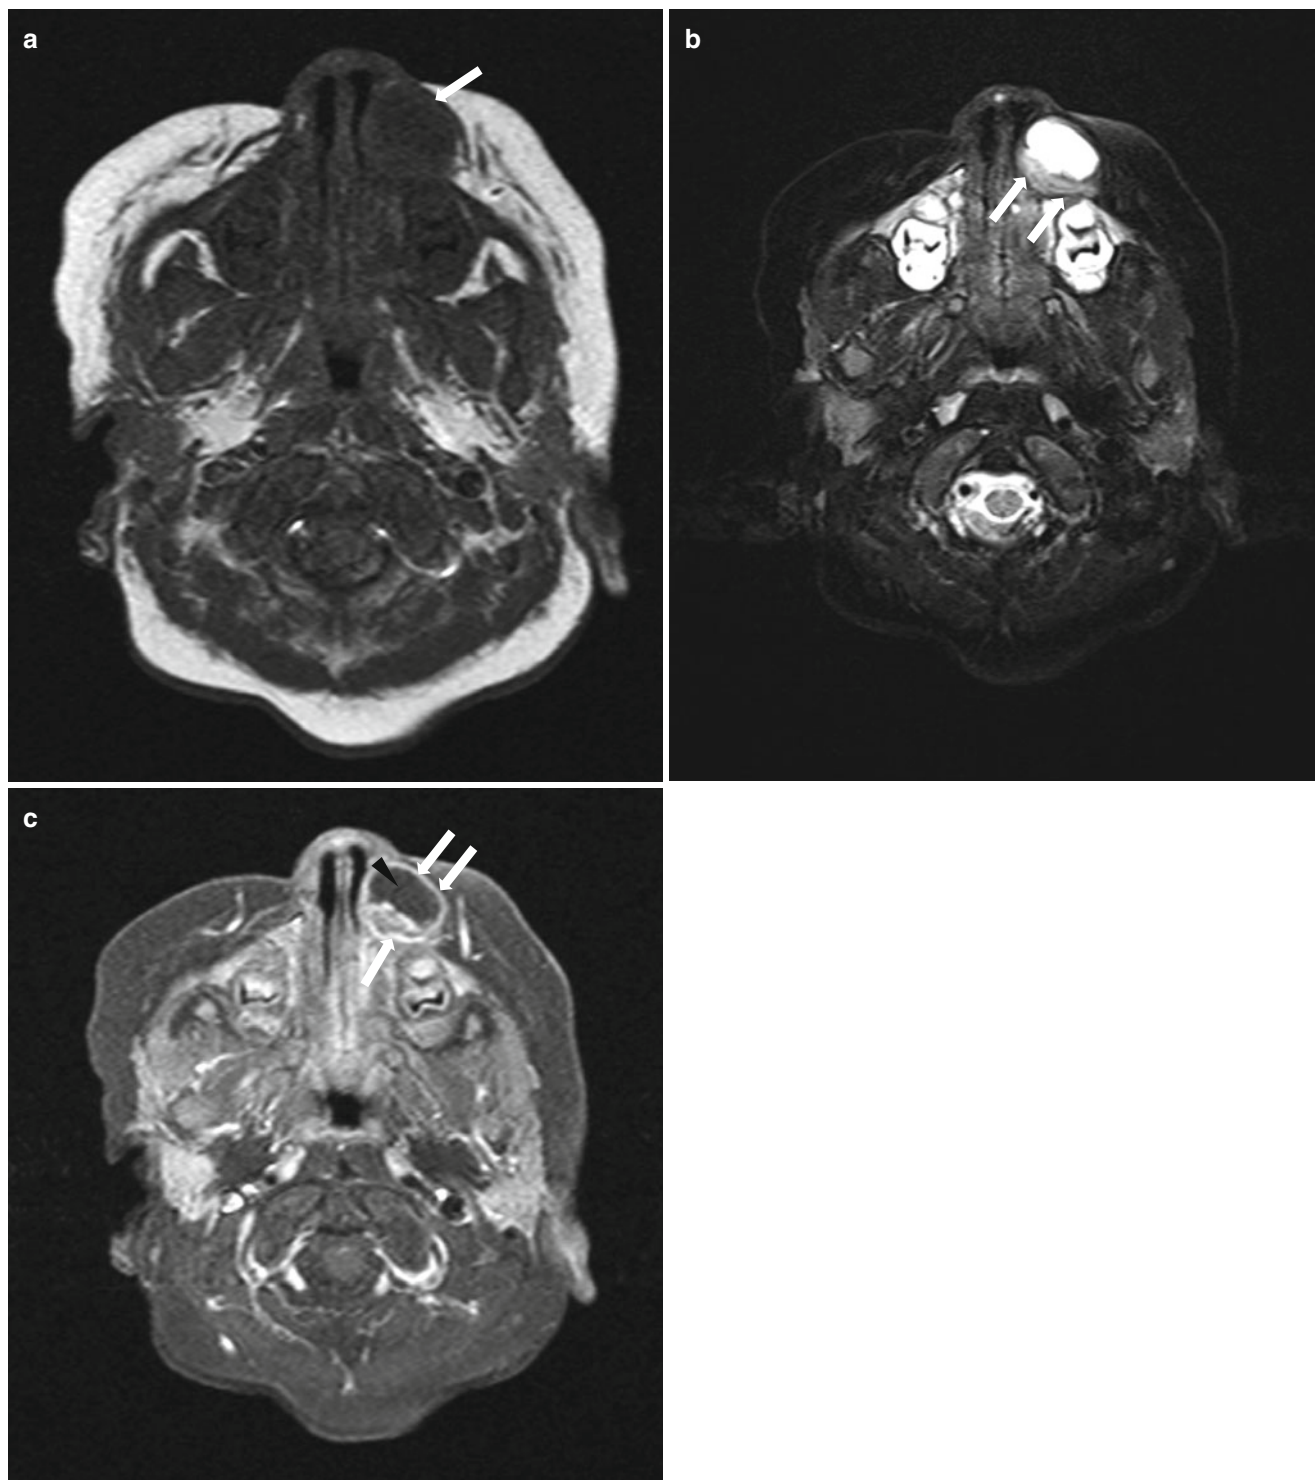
Nodular fasciitis in the face of a 9-month-old boy. (a) Axial T1-weighted MR image shows a mass in the left nasal ala (*arrow*). (b) Axial fat-suppressed T2-weighted MR image also shows a well-circumscribed lesion. Central portion of the lesion shows bright signal intensity (*arrowhead*). Periphery of the mass shows lower but high signal intensity as compared with the inner portion (*arrows*). (c) Axial
